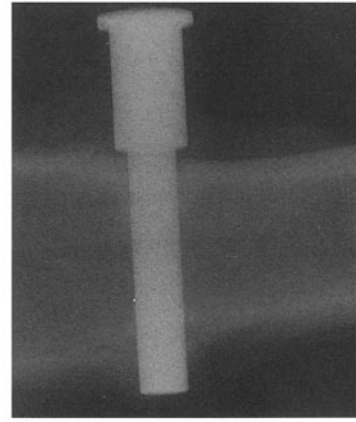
Radiograph demonstrating the dislocation of a tibia implant.
